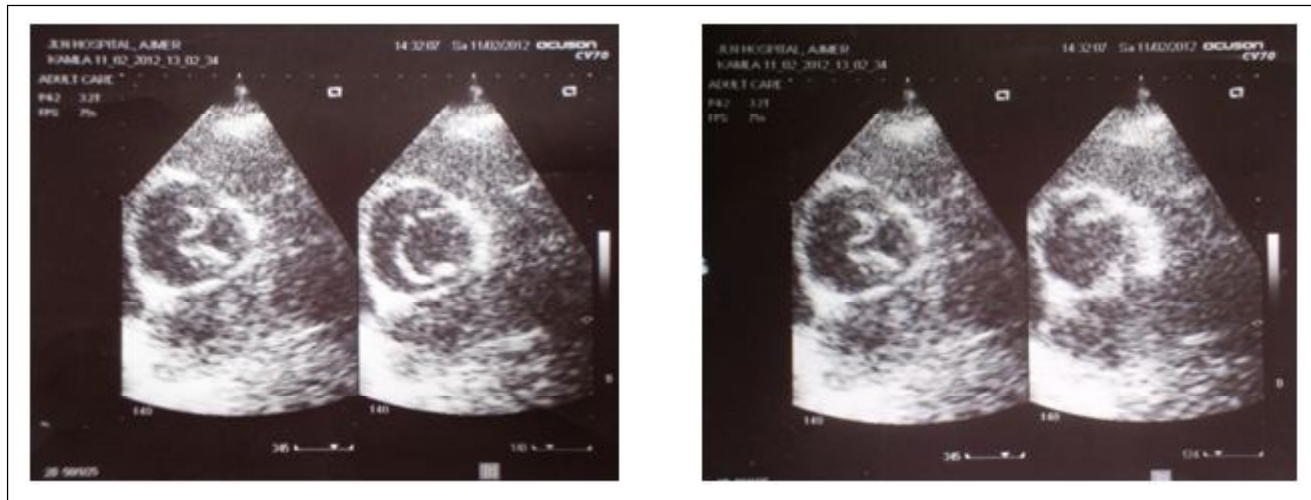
parasternal short axis view at aortic valve level confirms absent RCC with fusion of LCC& NCC.
